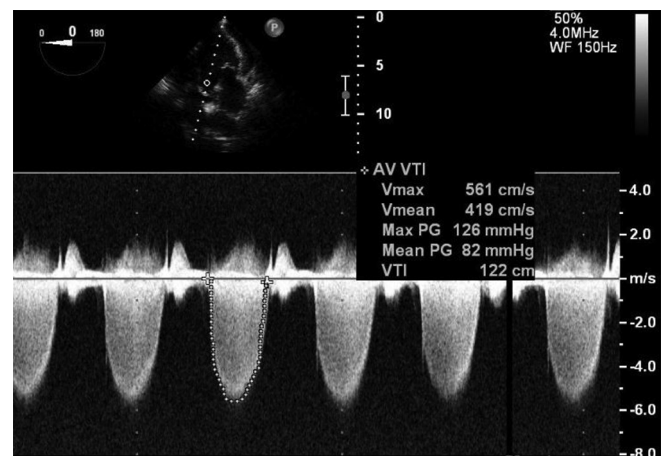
Preoperative peak (max PG) and mean gradient (mean PG) across aortic valve in deep transgastric view in transesophageal echocardiography
